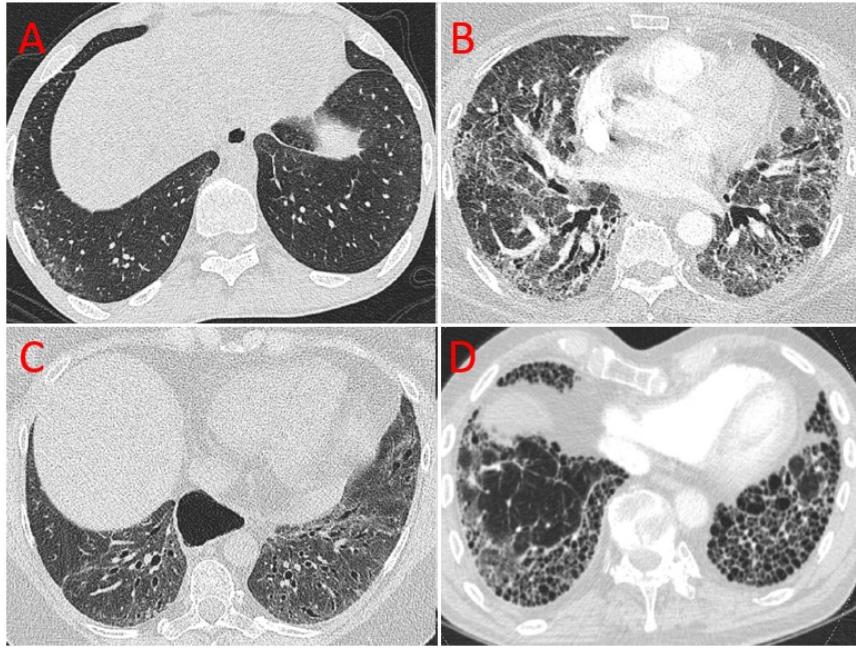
High resolution CT dicom's from four different patients with Scleroderma from the ILD-PH cohort.
